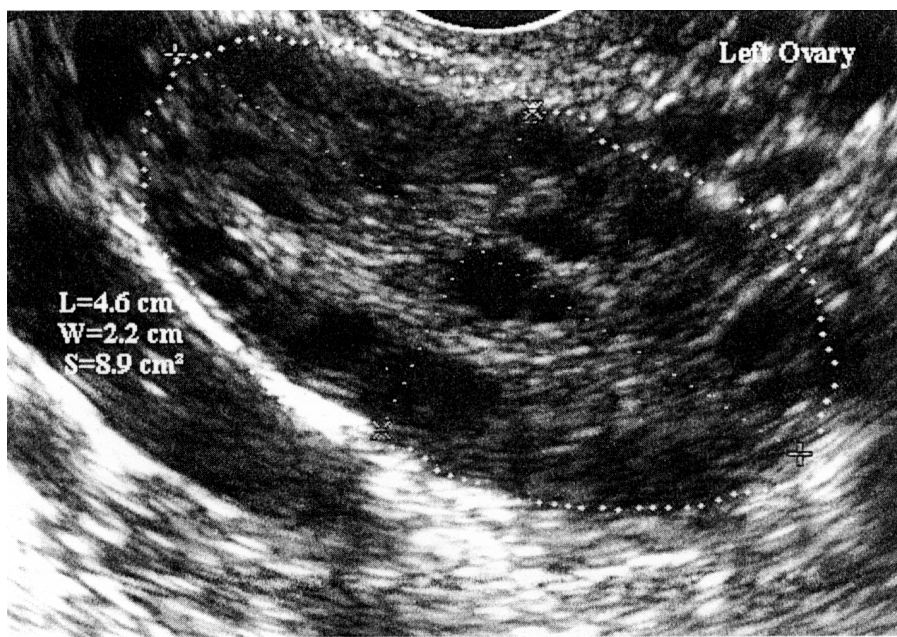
Ultrasound image of polycystic ovary. The ovarian length (4.6 cm) and width (2.2 cm) are increased as well as the ovarian area (8.9 cm²). The follicle number, with a diameter between 2 and 5 mm, is more than ten. The distribution within the ovary is mainly peripheral, but some follicles can be seen in the central part of the ovary. From Robert *et al.*, 2000.
